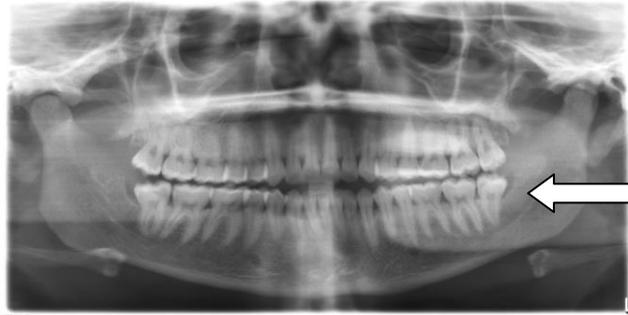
Panoramic radiograph showing vertical impaction in 38
